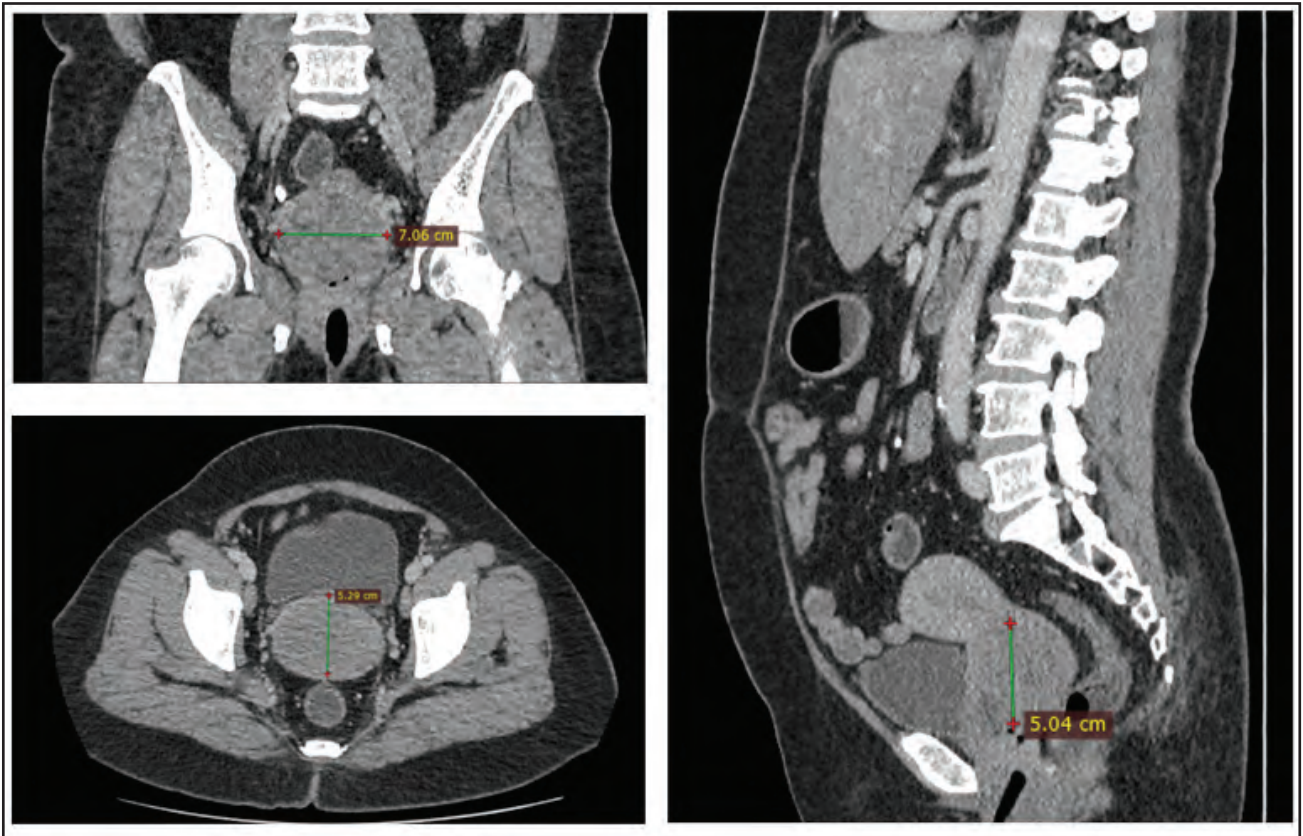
Computed tomography imaging of the case before treatment
